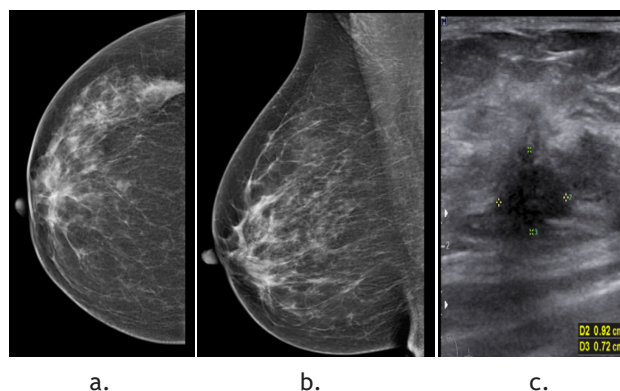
Screening mammogram (a and b) and sonogram (c) of a 50 year old lady with invasive lobular carcinoma asymmetry on CC view of MG. An ill defined hypoechoic mass is seen on sonogram (c). US guided biopsy was used for sampling. Final diagnosis: Invasive Lobular Carcinoma.
